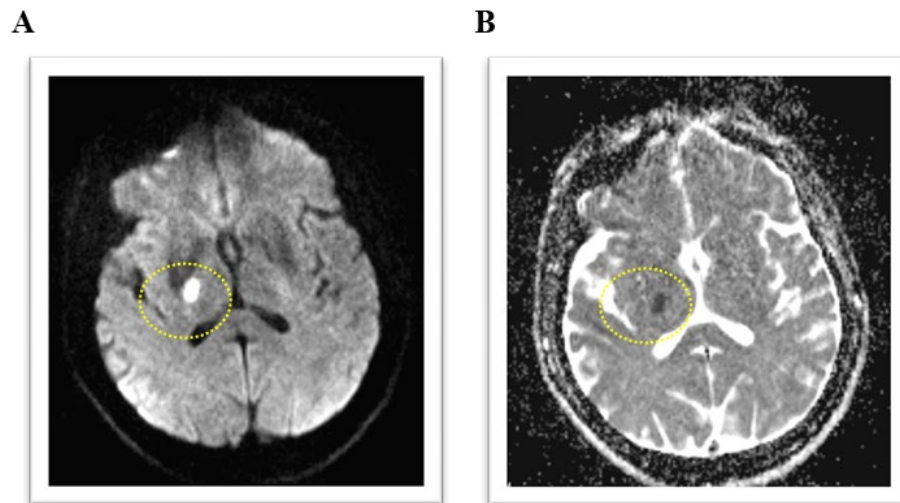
Brain diffusion MRI of Case 8 (A and B) showing right internal capsule infarct (as high lighted by yellow dotted circle).
